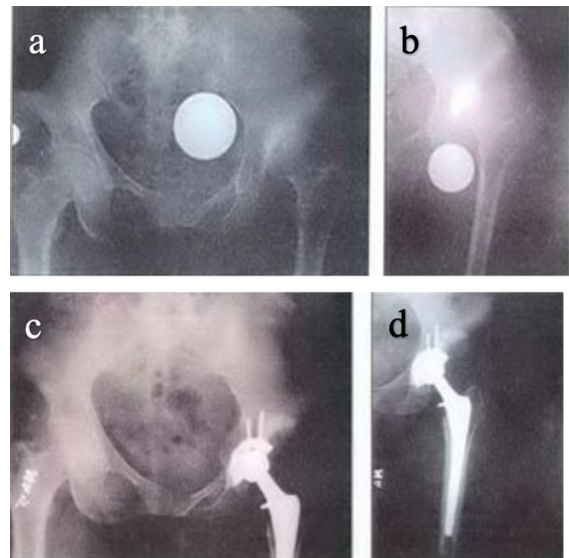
A 49-year-old female patient with left coxarthrosis secondary to DDH, preoperative anteroposterior pelvic x-ray (a), anteroposterior left hip x-ray (b), and 26-month postoperative control pelvic x-ray (c) and anteroposterior left hip x-ray (d)
